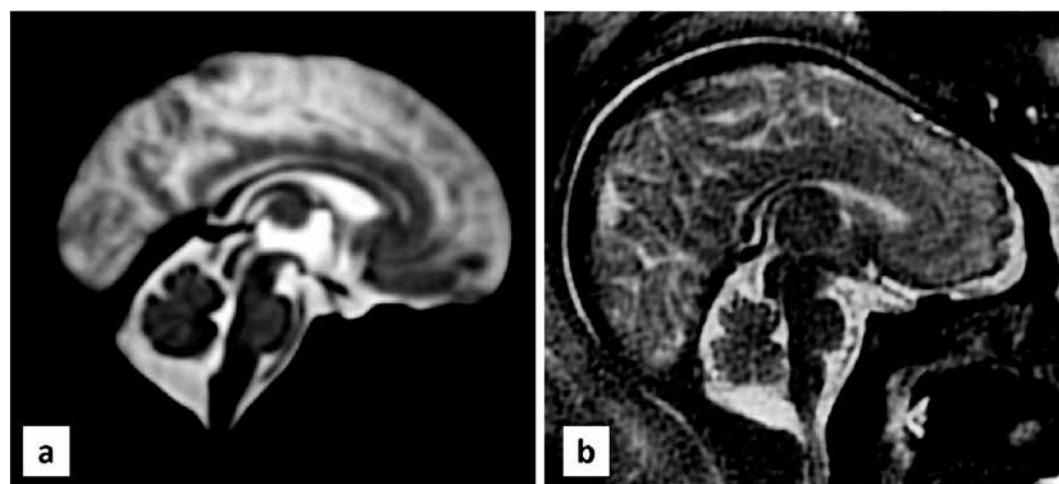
Magnetic resonance imaging of the human fetal brain (36 weeks of gestation), mid-sagittal plane: a – atlas "Fetal Brain Atlas" [24], b – database "Fetal Brain MRI from Stanford Lucile Packard Children's Hospital" [25, 26].
